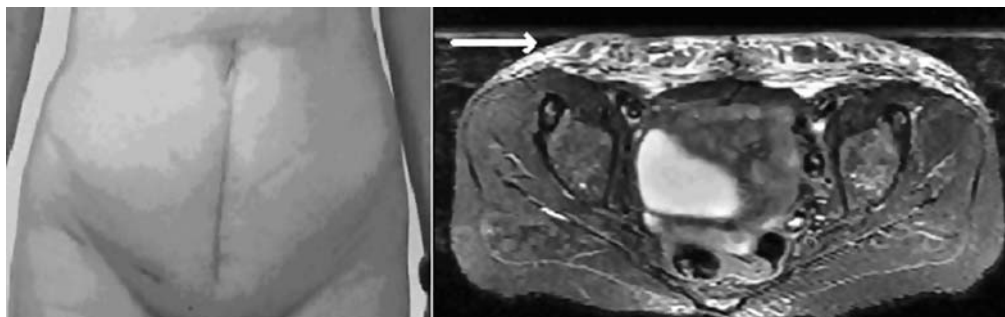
Left Panel:* Regional epifascial edema of anterior pelvis after regional lymphadenectomy for vaginal carcinoma, without LE of the lower extremities. *Right Panel:* Axial fat-suppressed inversion recovery MRI image of pelvis of same patient demonstrating anterior edema (Arrow).
